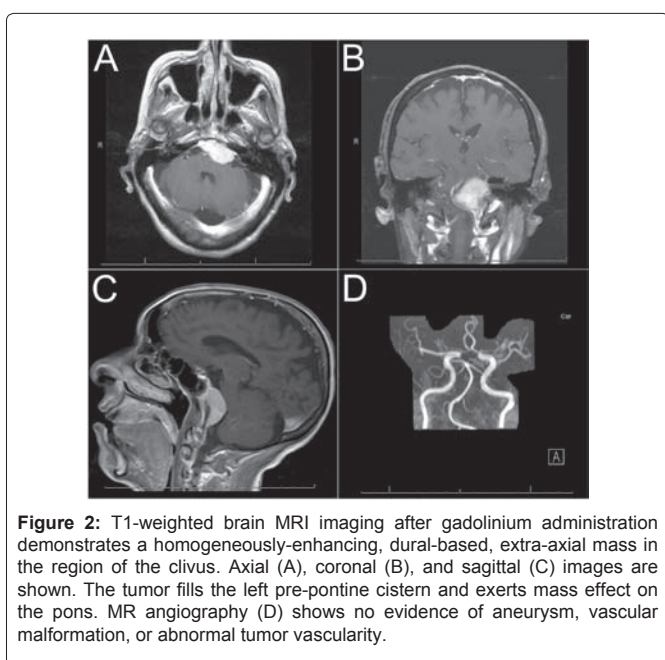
T1-weighted brain MRI imaging after gadolinium administration demonstrates a homogeneously-enhancing, dural-based, extra-axial mass in the region of the clivus. Axial (A), coronal (B), and sagittal (C) images are shown. The tumor fills the left pre-pontine cistern and exerts mass effect on the pons. MR angiography (D) shows no evidence of aneurysm, vascular malformation, or abnormal tumor vascularity.
